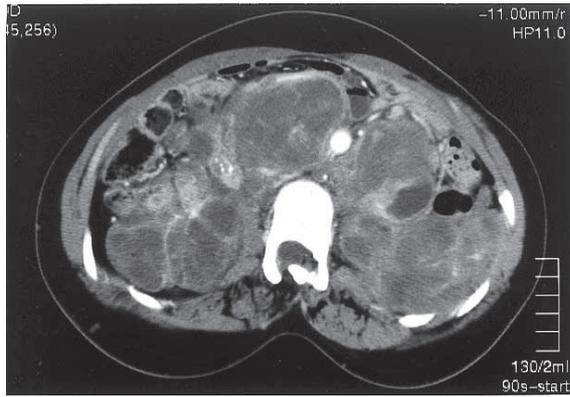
CT scan of the abdomen shows multiple and huge tumors extending from the retroperitoneum to the pelvis. Contrast-enhanced CT scan shows heterogeneous enhancement of tumors.
